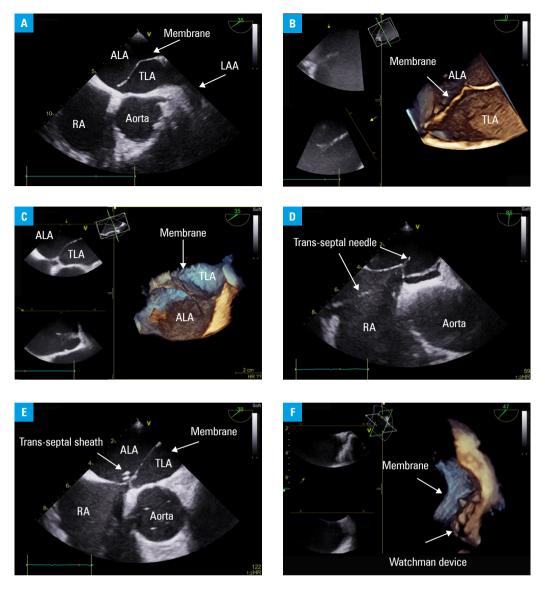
Transesophageal echocardiography during percutaneous left atrial appendage (LAA) closure;
